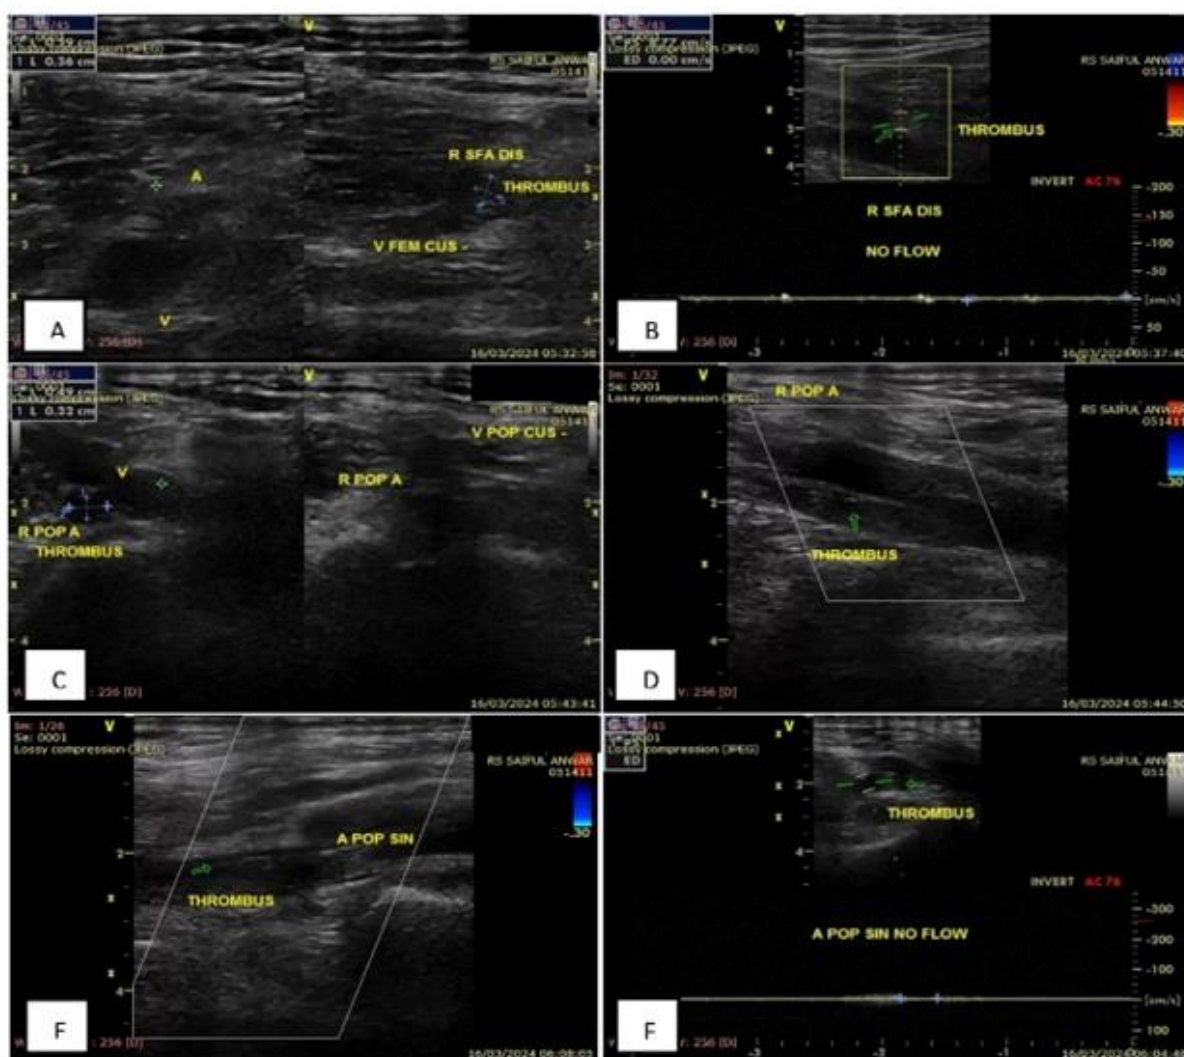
Doppler Ultrasound showed no flow and thrombus at the right superficial femoral artery (A,B), and right popliteal artery (C,D). Spectral Doppler no flow and thrombus at the left popliteal artery (E,F)
